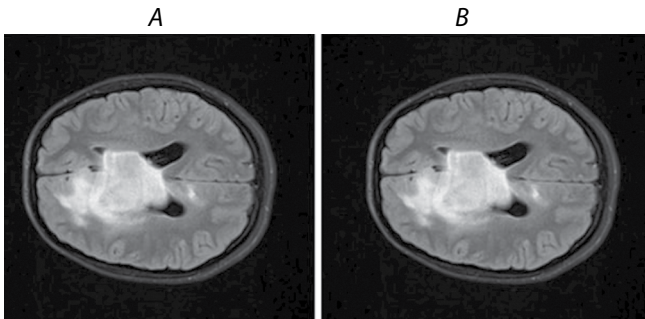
Diffuse glioma (T2-FLAIR, ax).
